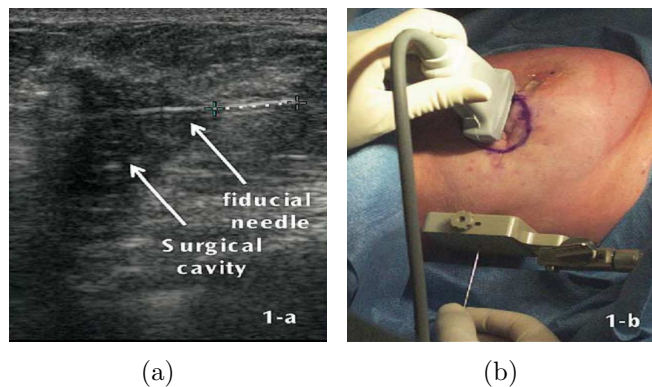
(a) The current permanent-seed breast implant technique uses a fiducial needle that is inserted under ultrasound (US) guidance. (b) Eventually, a template is attached and immobilized using a passive mechanical fixture [81].
